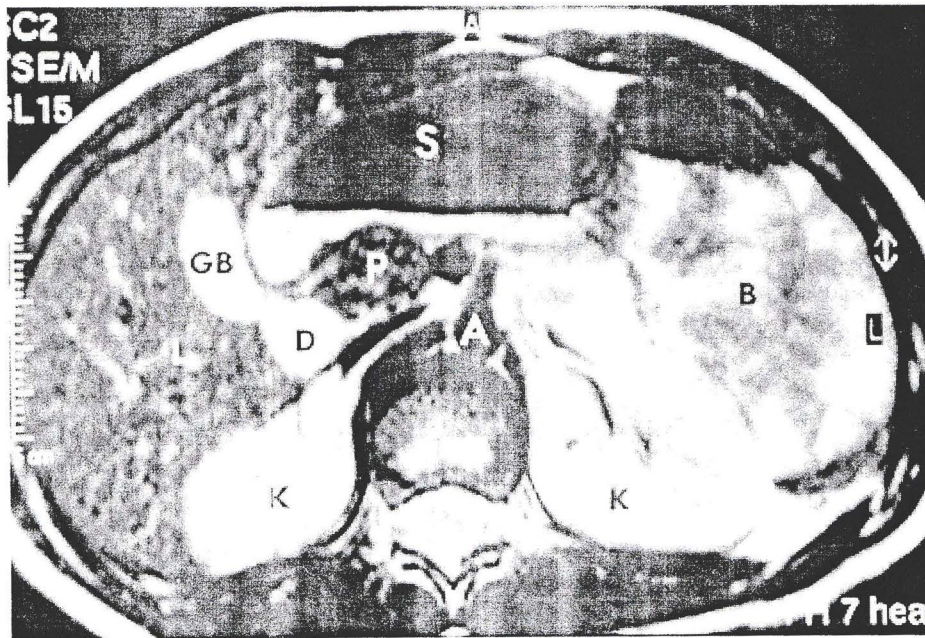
MRI showing the remnant of the pancreatic head (T2 weighted image at the level of the renal hila) 2 months after surgery in patient 7.
